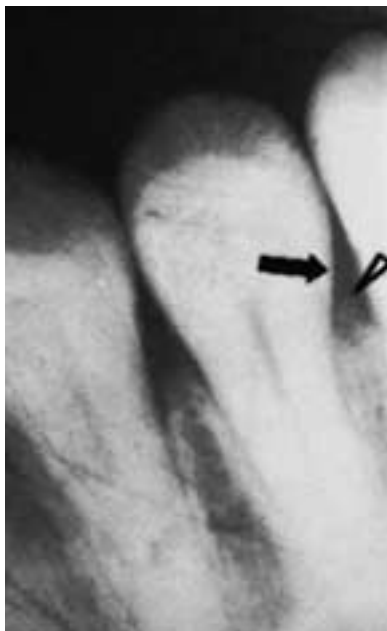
Periapical radiograph of mandibular first and second premolars. Cementoenamel junction (where enamel of tooth crown ends and cementum of root begins) (*black arrow*). The arrowhead points to the place where the alveolar crest of bone would normally be. Note that the bone is below this level secondary to loss from periodontal disease.
